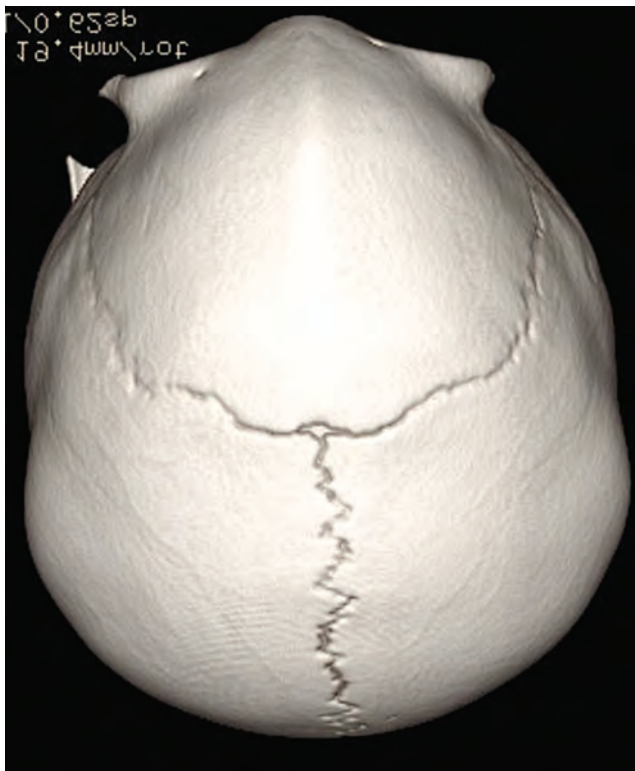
CT image demonstrating trigonocephaly.
